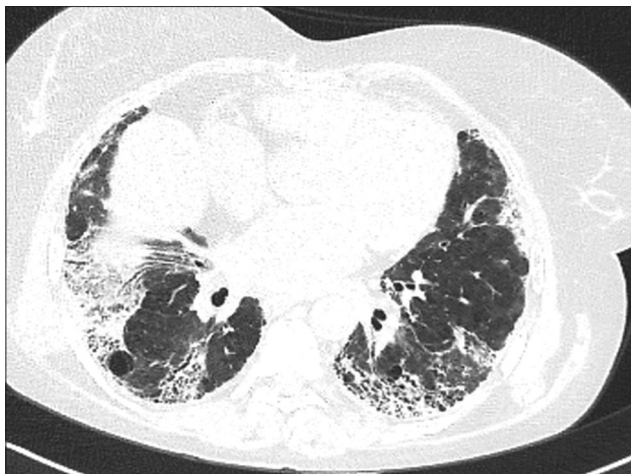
Fibrotic changes with bronchiolectasis and peribronchial thickening in the control chest computed tomography
